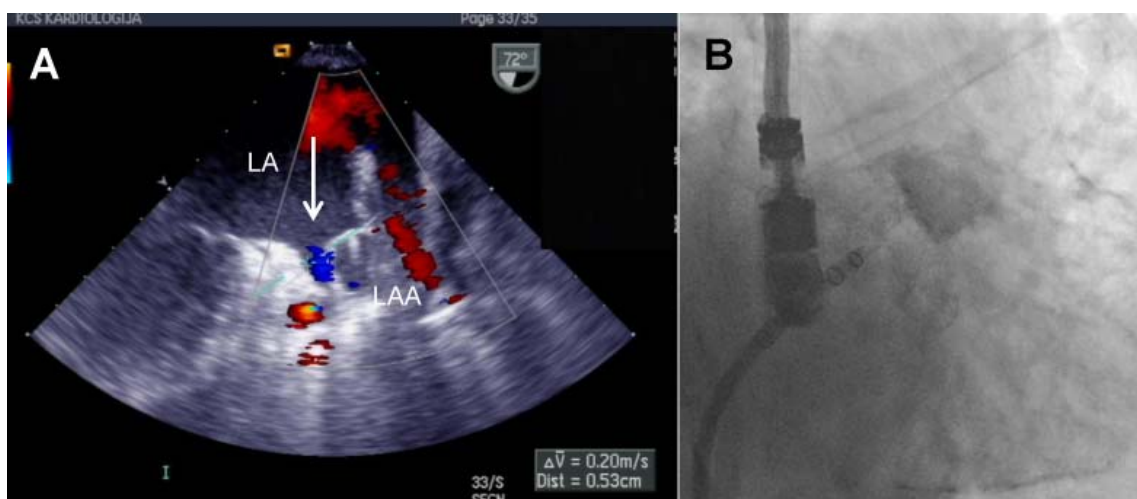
A) Transesophageal echocardiography showing the final position of the Watchman device (arrow); B) – Color Doppler echocardiography image showing the absence of residual shunt within the left atrial appendage.
